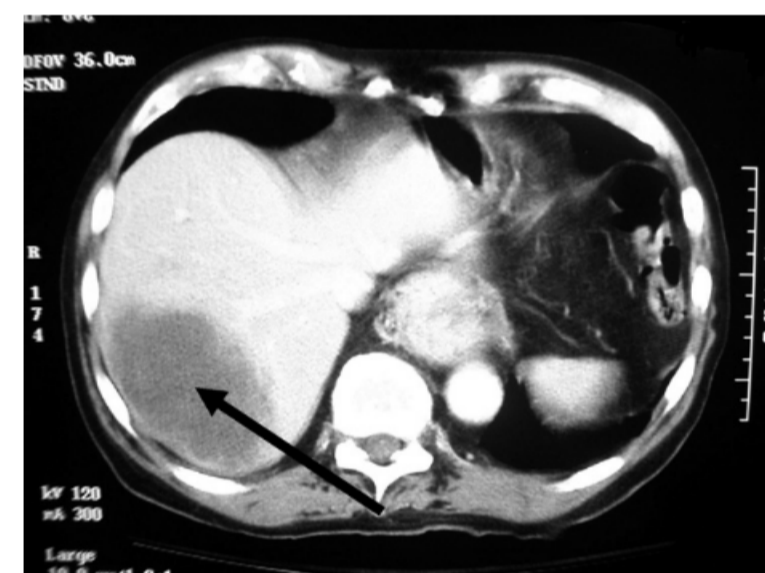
Trauma computed tomography scan showing an incidental liver mass (arrow) in an elderly male.
